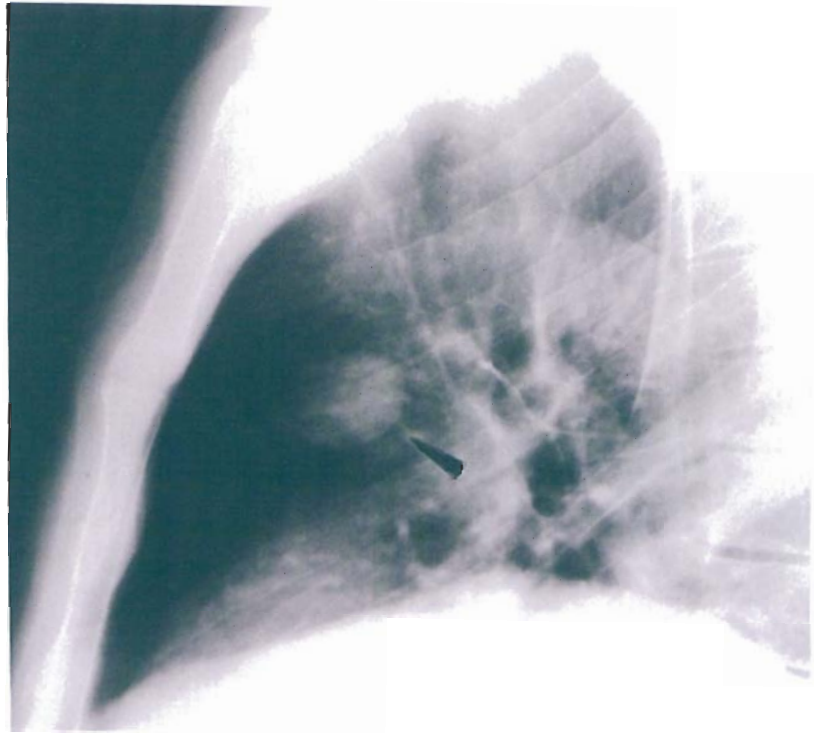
A sideways x-ray of a male patient aged 56 with a secondary in his chest from a bladder cancer. This has been proven by needle biopsy. His bladder was treated 3 years before for a Stage 3 primary cancer in the bladder and he has remained free of disease in the bladder since then.
